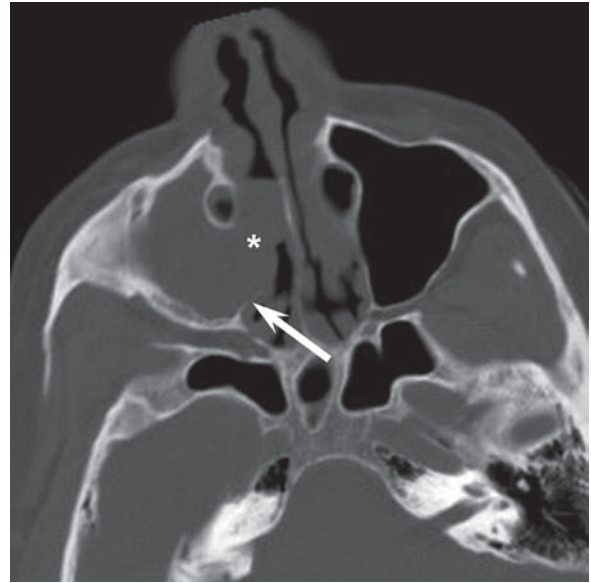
Antranasal polyp. Axial CT shows a mass filling the right maxillary sinus and extending into the nasal cavity (*asterisk*). The medial wall of the sinus is remodeled (*arrow*), indicating a benign etiology
